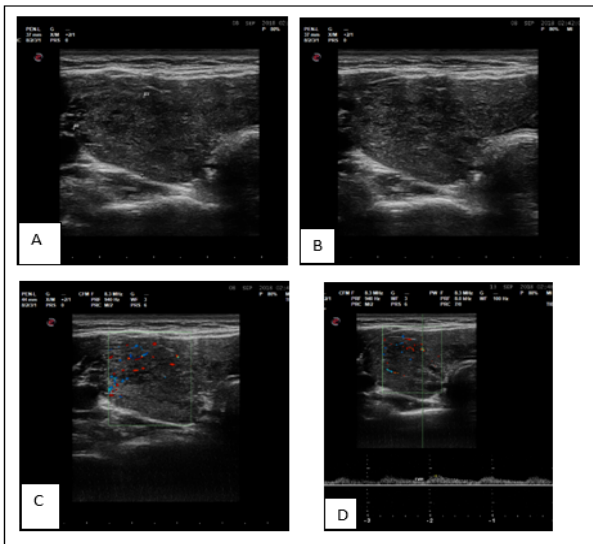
ATA Thyroid Nodule Sonographic Patterns - Low Suspicious. Pathological diagnosis - Hashimoto's thyroiditis - Bethesda II.
